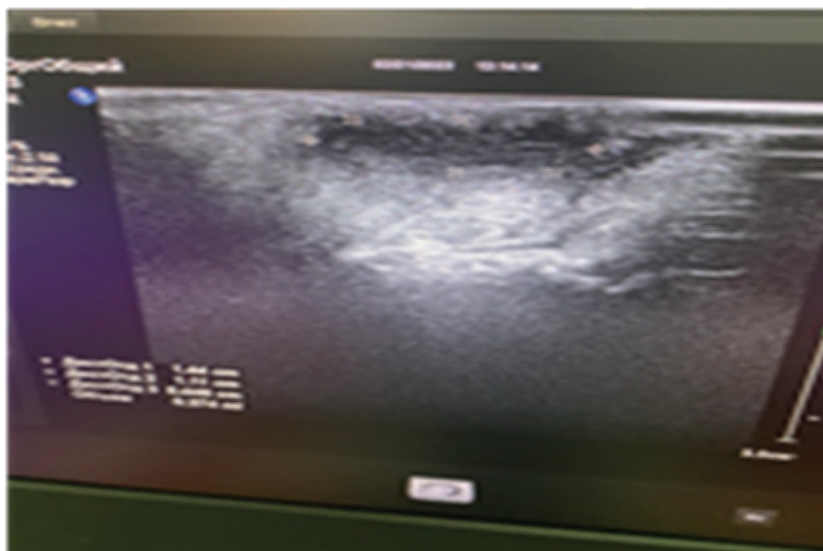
Sonogram of the epithelial coccygeal passage before surgery
